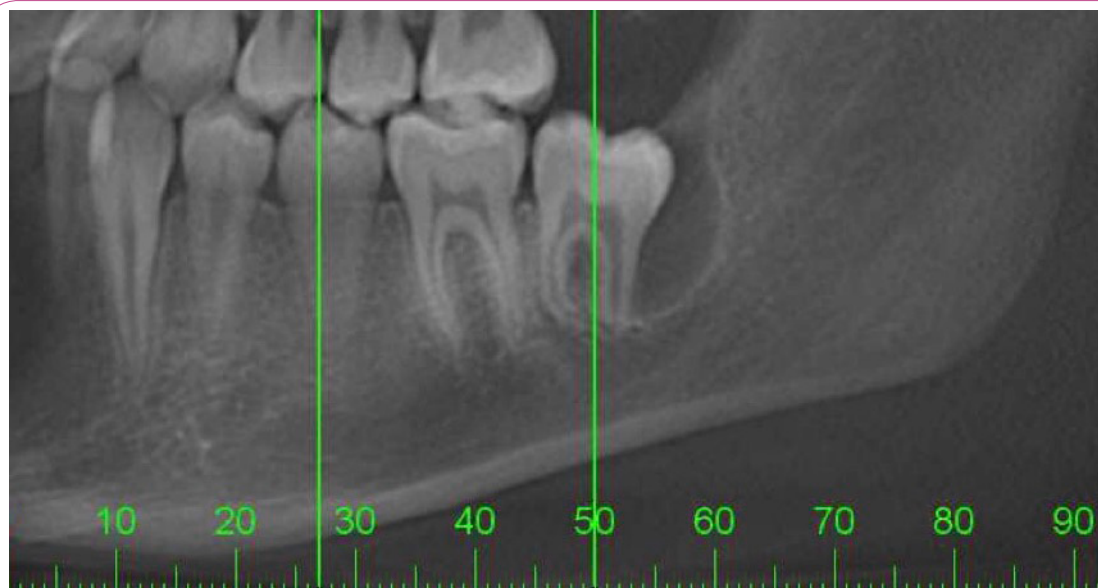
Sectional Orthopantomogram showing Well defined radiolucency distal of tooth 37.
